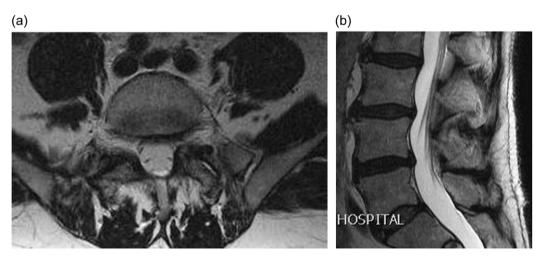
(a) Axial T2 weighted MRI showing complete resolution of the synovial cyst; (b) sagittal T2 weighted MRI showing complete resolution of the synovial cyst.
